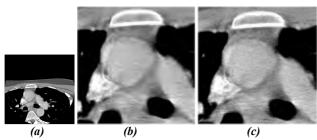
(a) original 3D CT sequence image, reconstructed image at compression ratio 20 (b) zoom on JPEG2000, (c) zoom on 3D codec.
